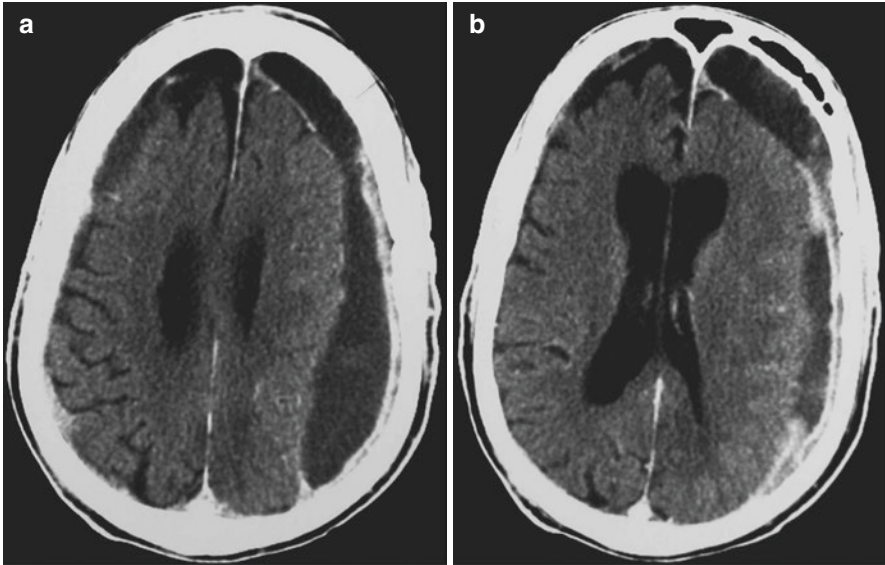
Postoperative subdural empyema in an 80-year-old man operated 4 weeks before for a chronic subdural hematoma. Axial cranial CT scan with contrast injection (a, b). (Reproduced from Akhaddar A (editor) Atlas of Infections in Neurosurgery and Spinal surgery (2017). Springer International Publishing; with permission)
